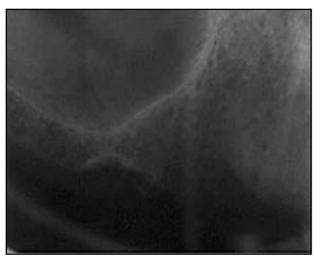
Periapical radiography exhibiting no osseous involvement and an osteogenic reaction of the alveolar bone
